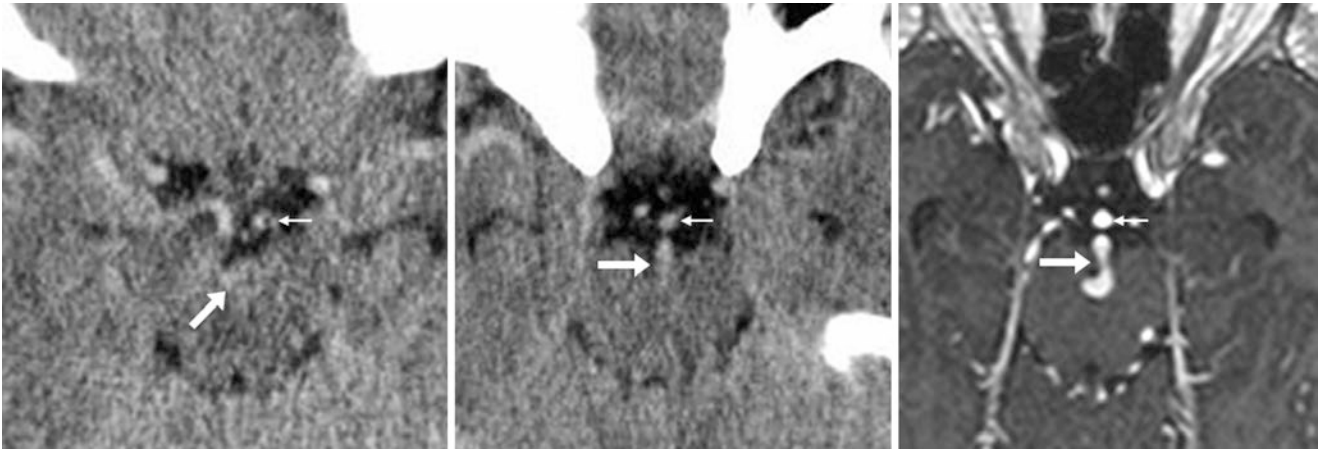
38-year-old with severe headache. On nonenhanced CT (*left*), a subtle hyperdensity within the interpeduncular fossa was called a tiny focus of SAH, but a slightly more caudal image (*middle*) depicted
